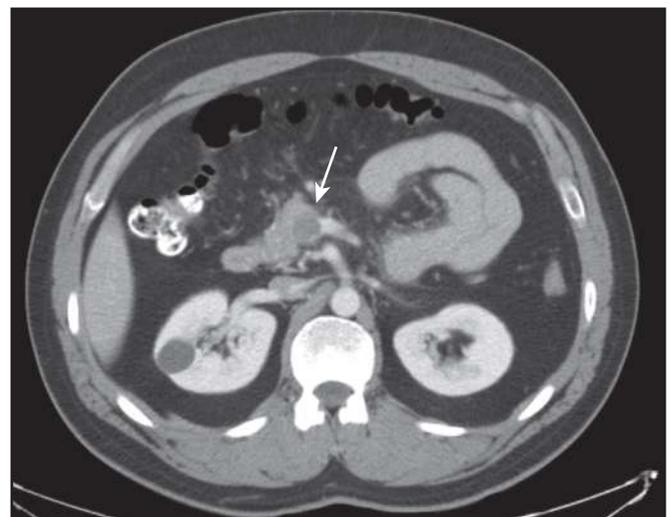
CT scan of a patient with mesenteric venous thrombosis. Note the thrombus in the superior mesenteric vein at its confluence with the splenic vein, as shown with the arrow.
